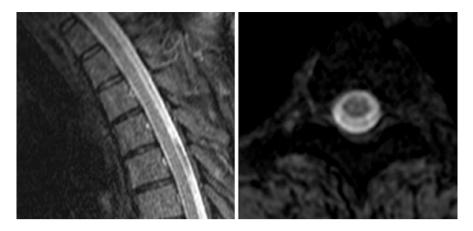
Patient developed acute back pain after a lifting episode followed by a positional headache consistent with low cerebrospinal fluid (CSF) tension. Magnetic resonance imaging findings demonstrate longitudinal CSF collection in subdural space of the thoracic spine
